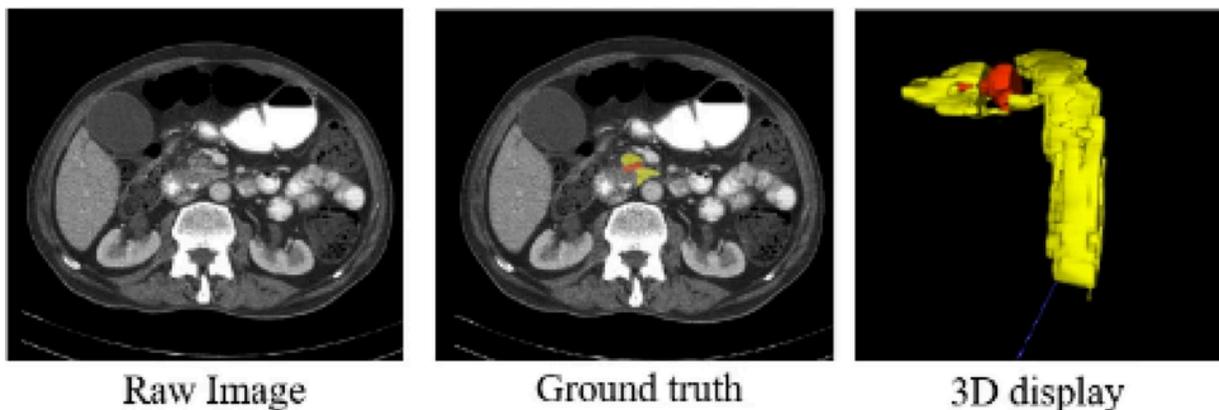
PDAC CT Scan Example*
